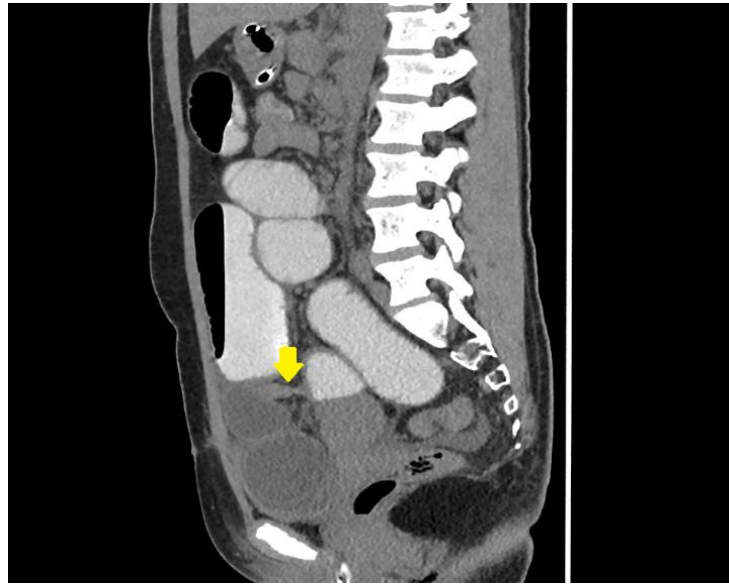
sagittal CT image of the abdomen shows A fibrous band arising from a Meckel's diverticulum (yellow arrow) is seen encircling the distal ileal loops, forming the transition point. Dilated fluid-filled loop of obstructed small bowel below this point, consistent with a closed-loop obstruction., contrast-filled proximal small bowel loops are observed above the site of obstruction.
